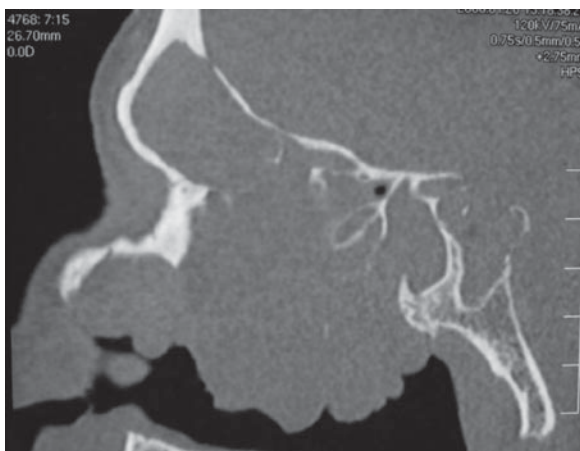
Parasagittal CT scan showing complete opacification of all sinuses and massive nasal polyposis filling the nasal cavity in a patient with multiple previous standard FESS procedures
